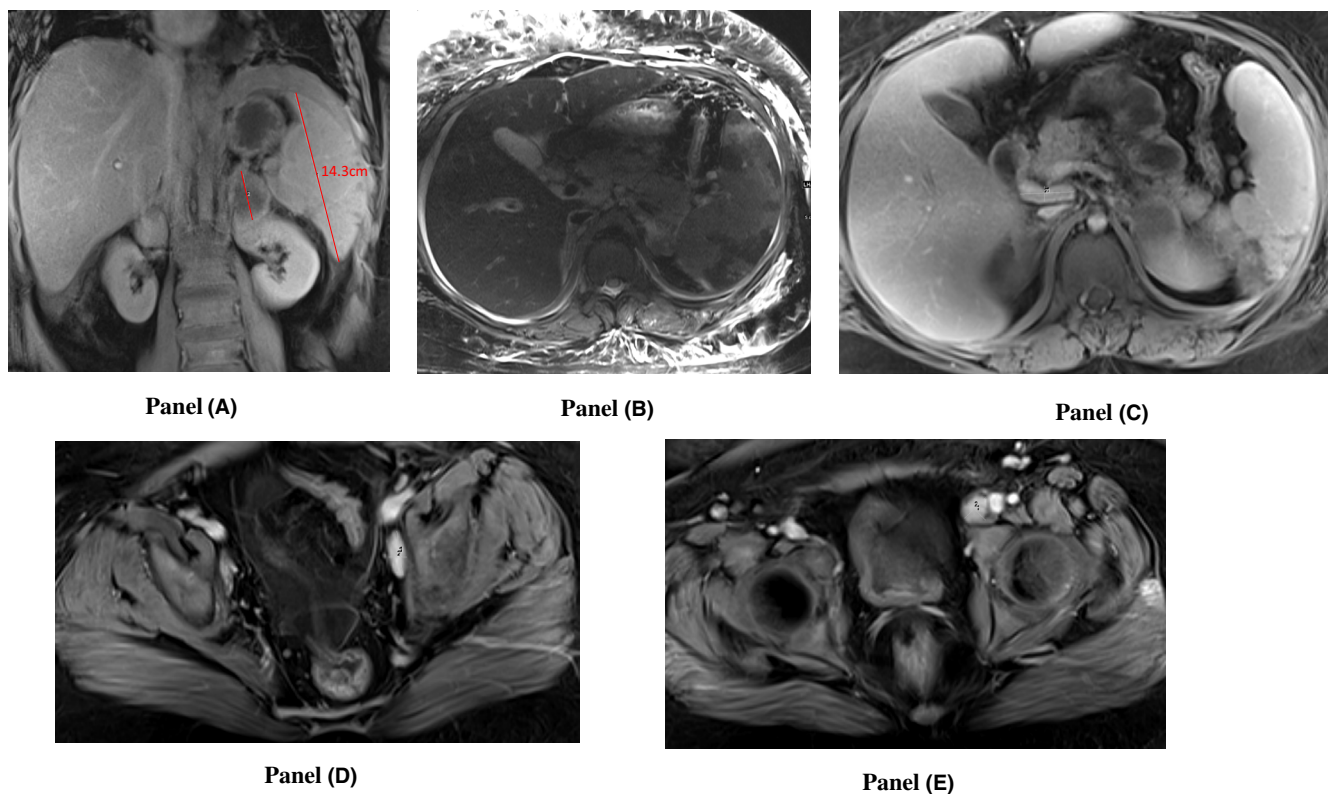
Initial abdominal and pelvic MRI. (A) Splenomegaly present with craniocaudal length of 14.3 cm and left adrenal gland with presence of a circumscribed lesion without additionally discerning features. (B) patchy confluent and geographic peripheral segmental T2 dark hypo-enhancing regions typical for splenic infarcts without discrete splenic mass. (C) Mildly enlarged lymph nodes present throughout abdomen most notably in the pelvis porta hepatis. (D) Left pelvic sidewall lymph node. (E) Left external iliac chain lymph node. Radiographic interpretation credit: Dr. Adam Bobby
